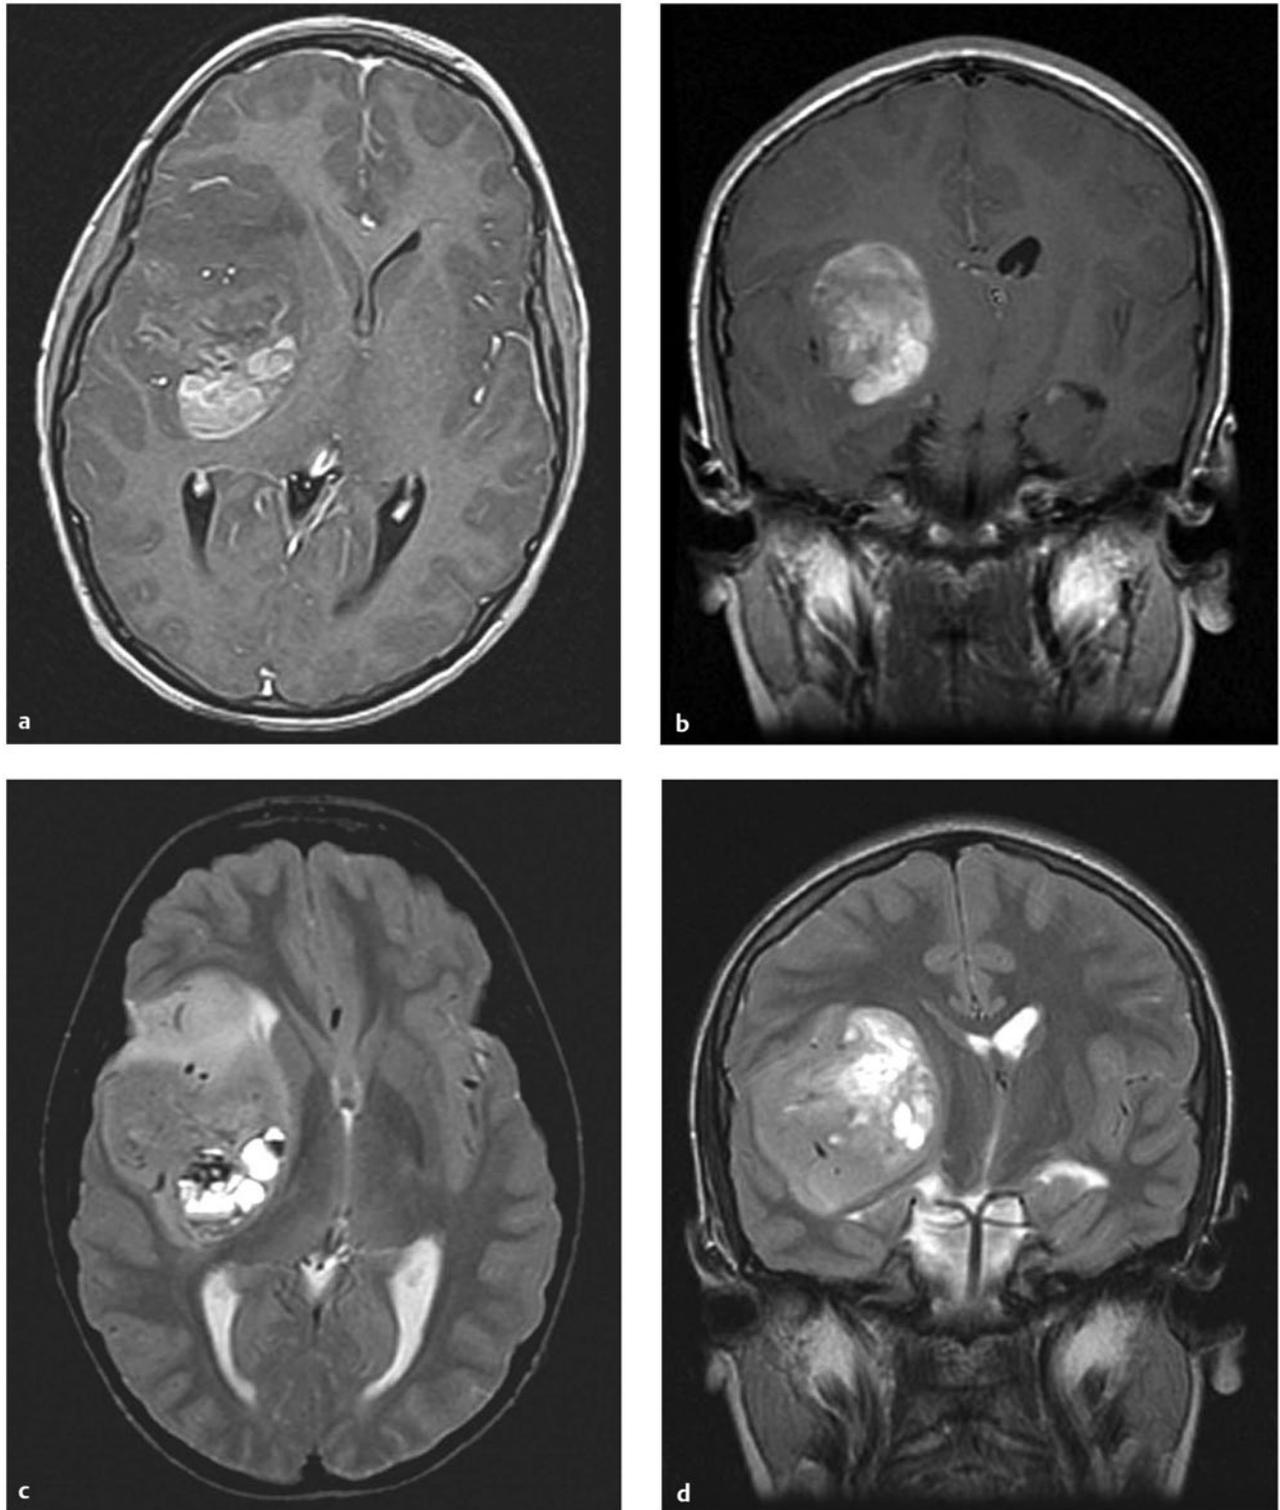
Supratentorial ependymoma. (a) Axial T1-weighted magnetic resonance (MR) image with gadolinium shows a hemispheric mass lesion, partially enhancing, partially nonenhancing, in the right frontal operculum. (b) Coronal T1-weighted MR image with gadolinium. (c) Axial T2-weighted MR image. Note the paucity of peritumoral edema. (d) Coronal T2-weighted MR image.
